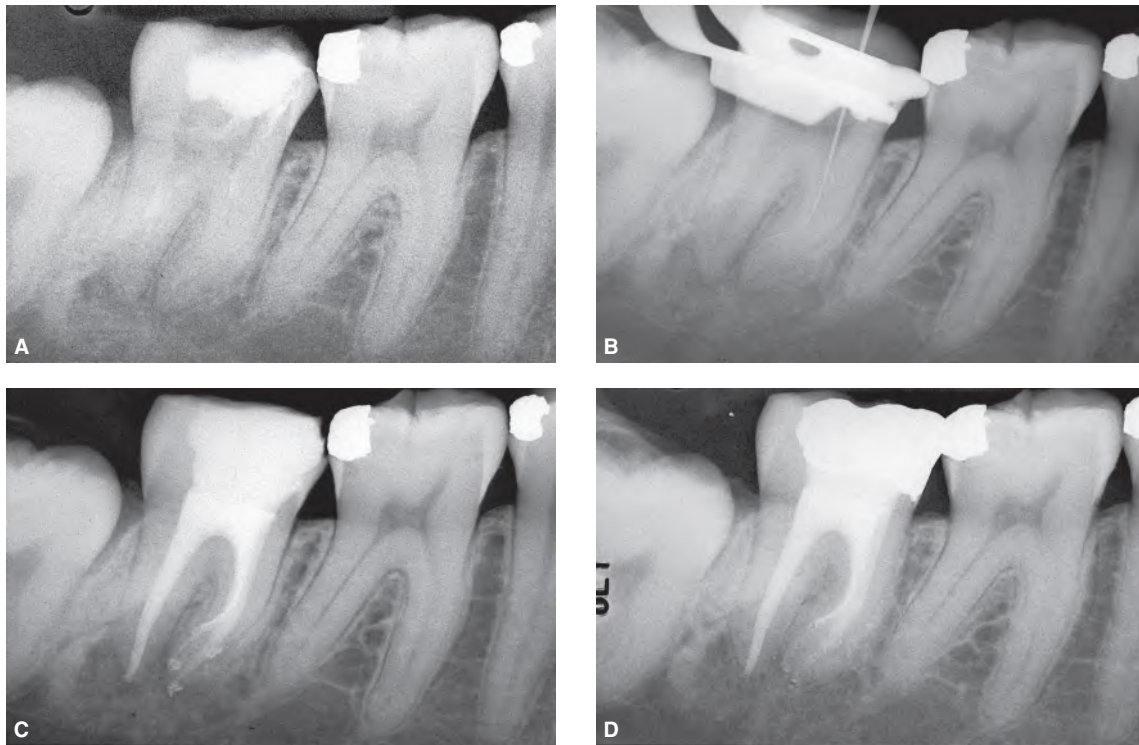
A*. Preoperative radiograph of a mandibular right second molar requiring retreatment. *B*. A marked bayonette curvature of the mesiolingual canal was detected. The apical third of this canal was cleaned and shaped only with #08 and 10 K-type files. *C*. Postoperative radiograph. The distal and mesiobuccal canals have been obturated using the Schilder's warm gutta-percha technique, while the mesiolingual canal was filled with thermoplastic gutta-percha. *D*. Three-year follow-up radiograph showing successful results.
